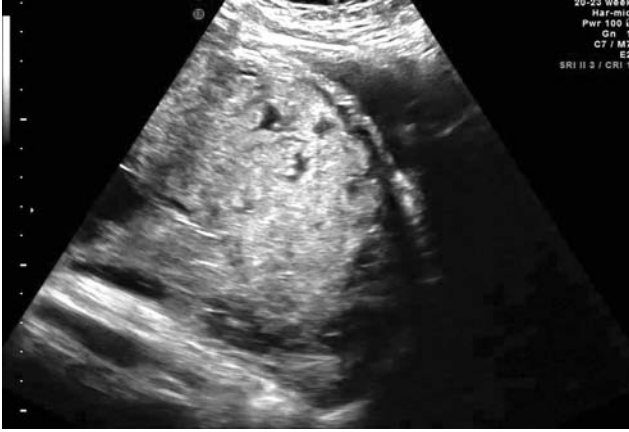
Ultrasound image of a case with confirmed placenta accreta. Note the echo-lucent spaces (lacunae) in the placental substance.
